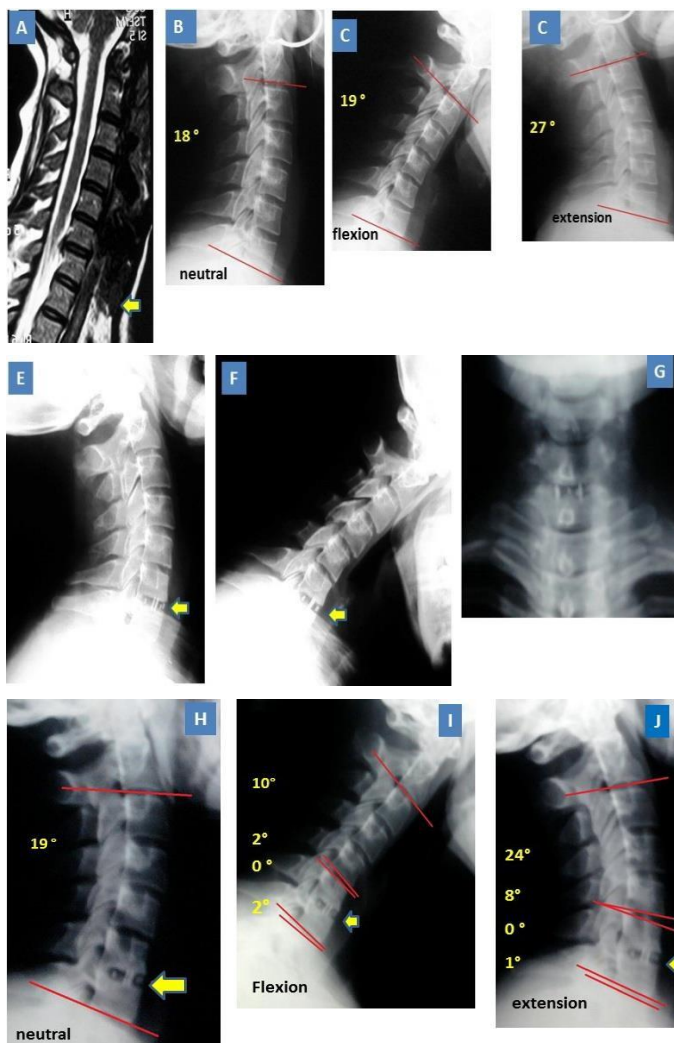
40 ys old lady with C6-7 DDD., treated by ACDF. (1) Preop. MRI, (2) preop. lateral neutral view: 18 ° overall alignment, (3&4) preop. dynamic views: 46 ° GROM, (5,6,7) 1 y postop.: good position of cage, (8) final lateral view: 19 ° overall lordosis, and good C6-7 fusion (9&10) final dynamic views: fused treated level, 34 ° GROM, and no adjacent levels hypermobility.
